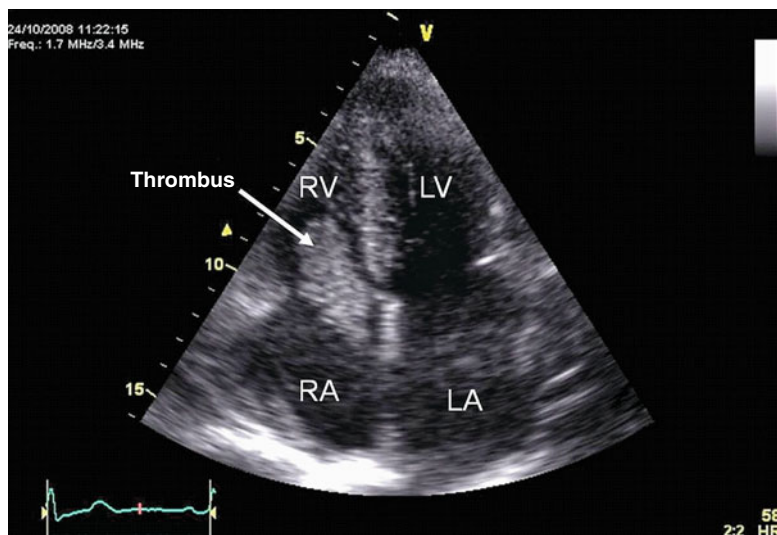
Transthoracic echo image showing thrombus within the right atrium in a patient with APC Fontan circulation. RA right atrium, LA left atrium, LV left ventricle (Image courtesy Justin O’Leary, The Heart Hospital, UCLH)
